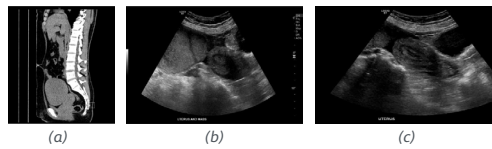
Non-contrast CT scan image showed the mass originating from the uterus. (b) A transabdominal ultrasound scan showed the being pedunculated from the uterine fundus. (c) Applying compression revealed the mass as being completely separable from the uterus.
